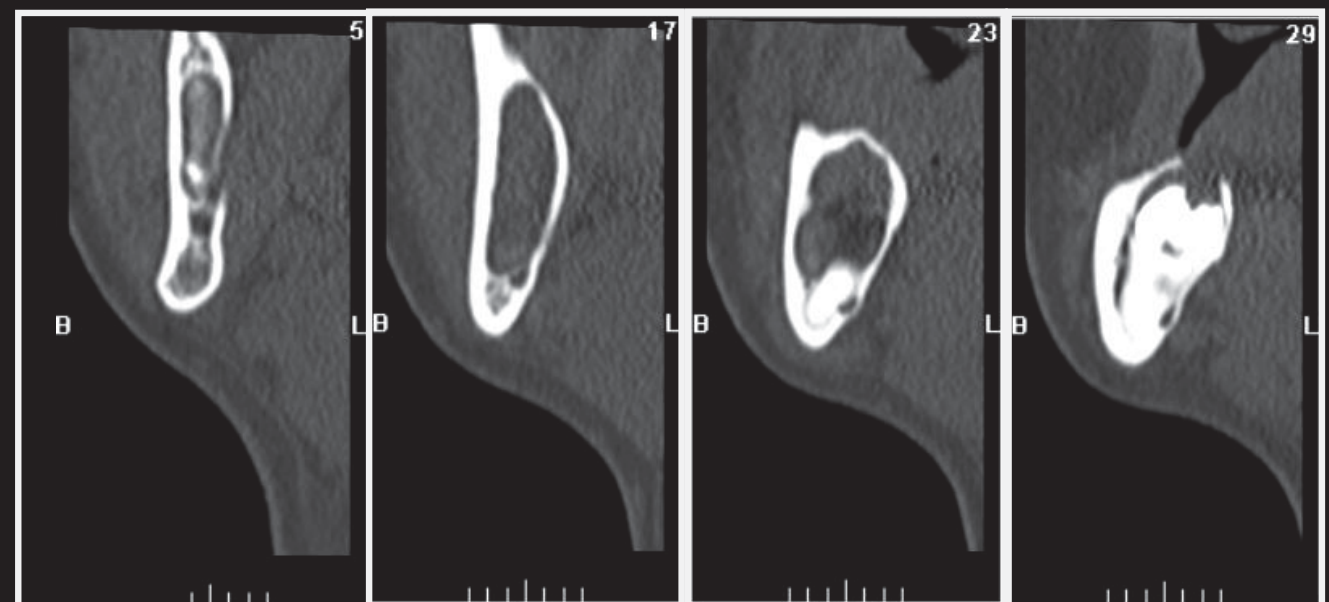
CT - Sagittal cuts.
